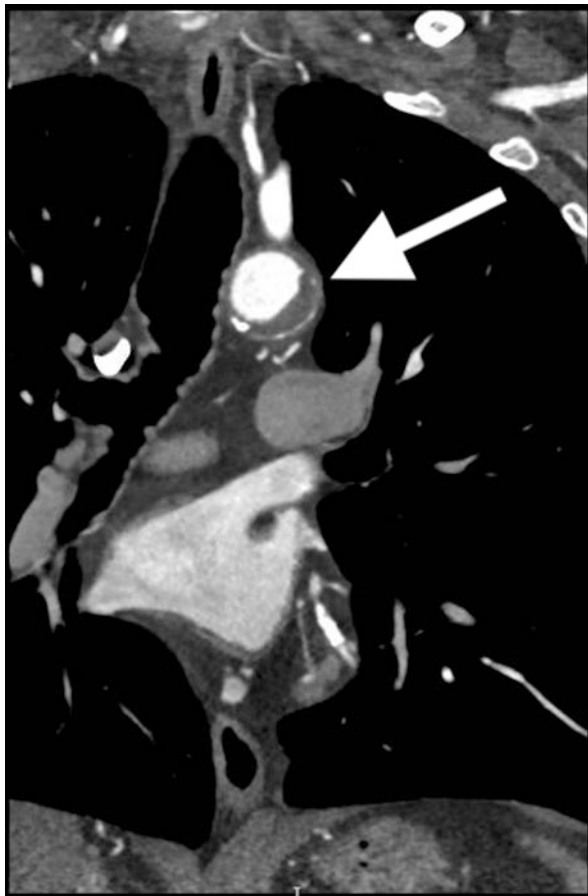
CT angiography transverse cut in which an intramural hematoma is identified. A large hematoma (arrow) is seen at the aortic walls, along with some atherosclerotic plaque
